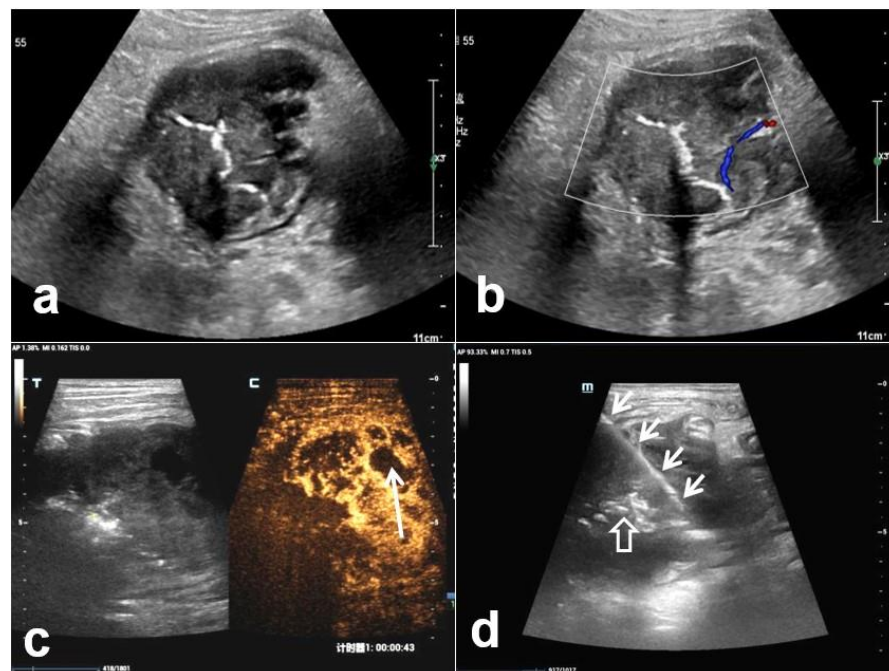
Ultrasound manifestation of the tumor: (a) 2D-image, the tumor seemed homogeneous. (b) Color Doppler image: Sparse blood flow signal observed inside the tumor. (c) Contrast-enhanced ultrasonography: Scattered necrotic area showed as dark area (arrow). (d) Ultrasound-guided biopsy: biopsy needle (arrow), gas line in the colonic lumen (hollow arrow)
